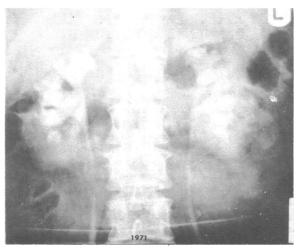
Intravenous urogram (February 1971) showing caliceal dilatation more widespread than before. Both kidneys were smaller, length of the left kidney being 23 mm less than in 1967. (Radiograph obtained with comparable dose of contrast medium and at comparable time in examination as in Fig. 1, abdominal compression being applied.)
